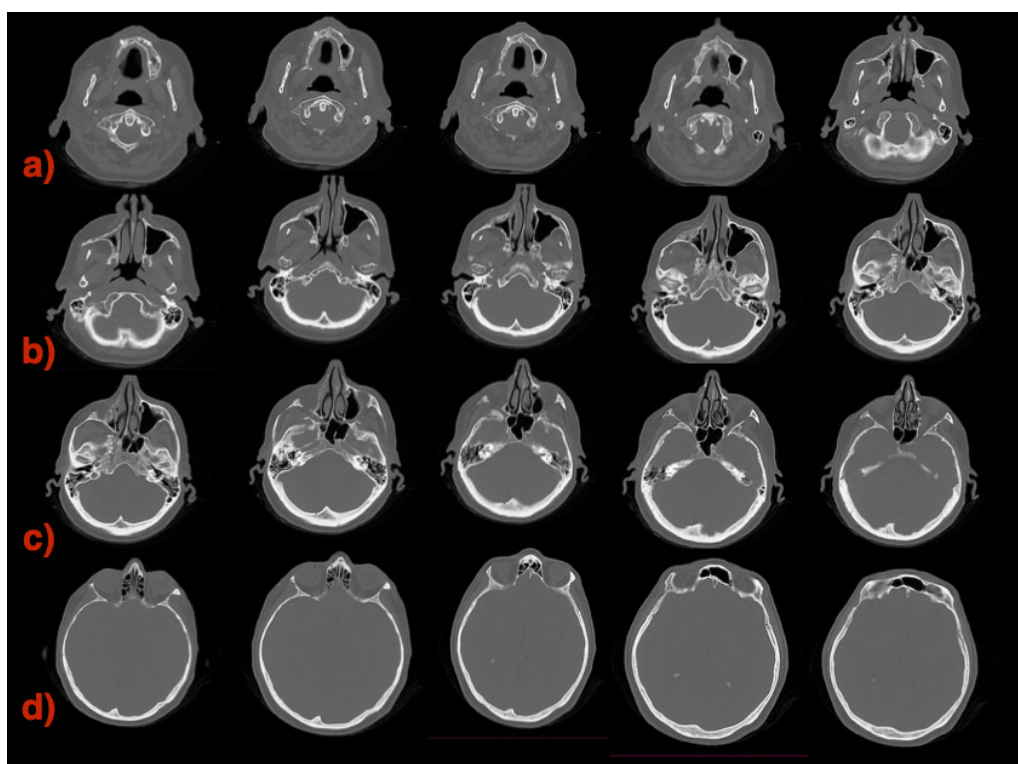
CT after 12 months. Reparative sclerosis in the alveolar bone, palate, zygomatic bone, and orbital bone is initially involved in an osteolytic alteration.
